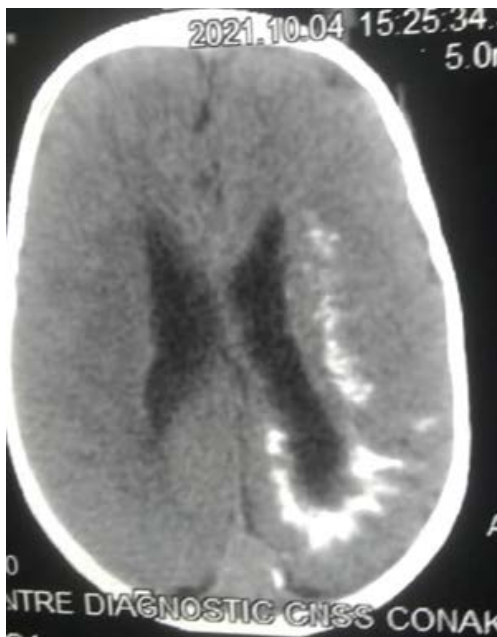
Cerebral CT without injection which highlights spontaneous subcortical hyper density around the left lateral ventricle.
